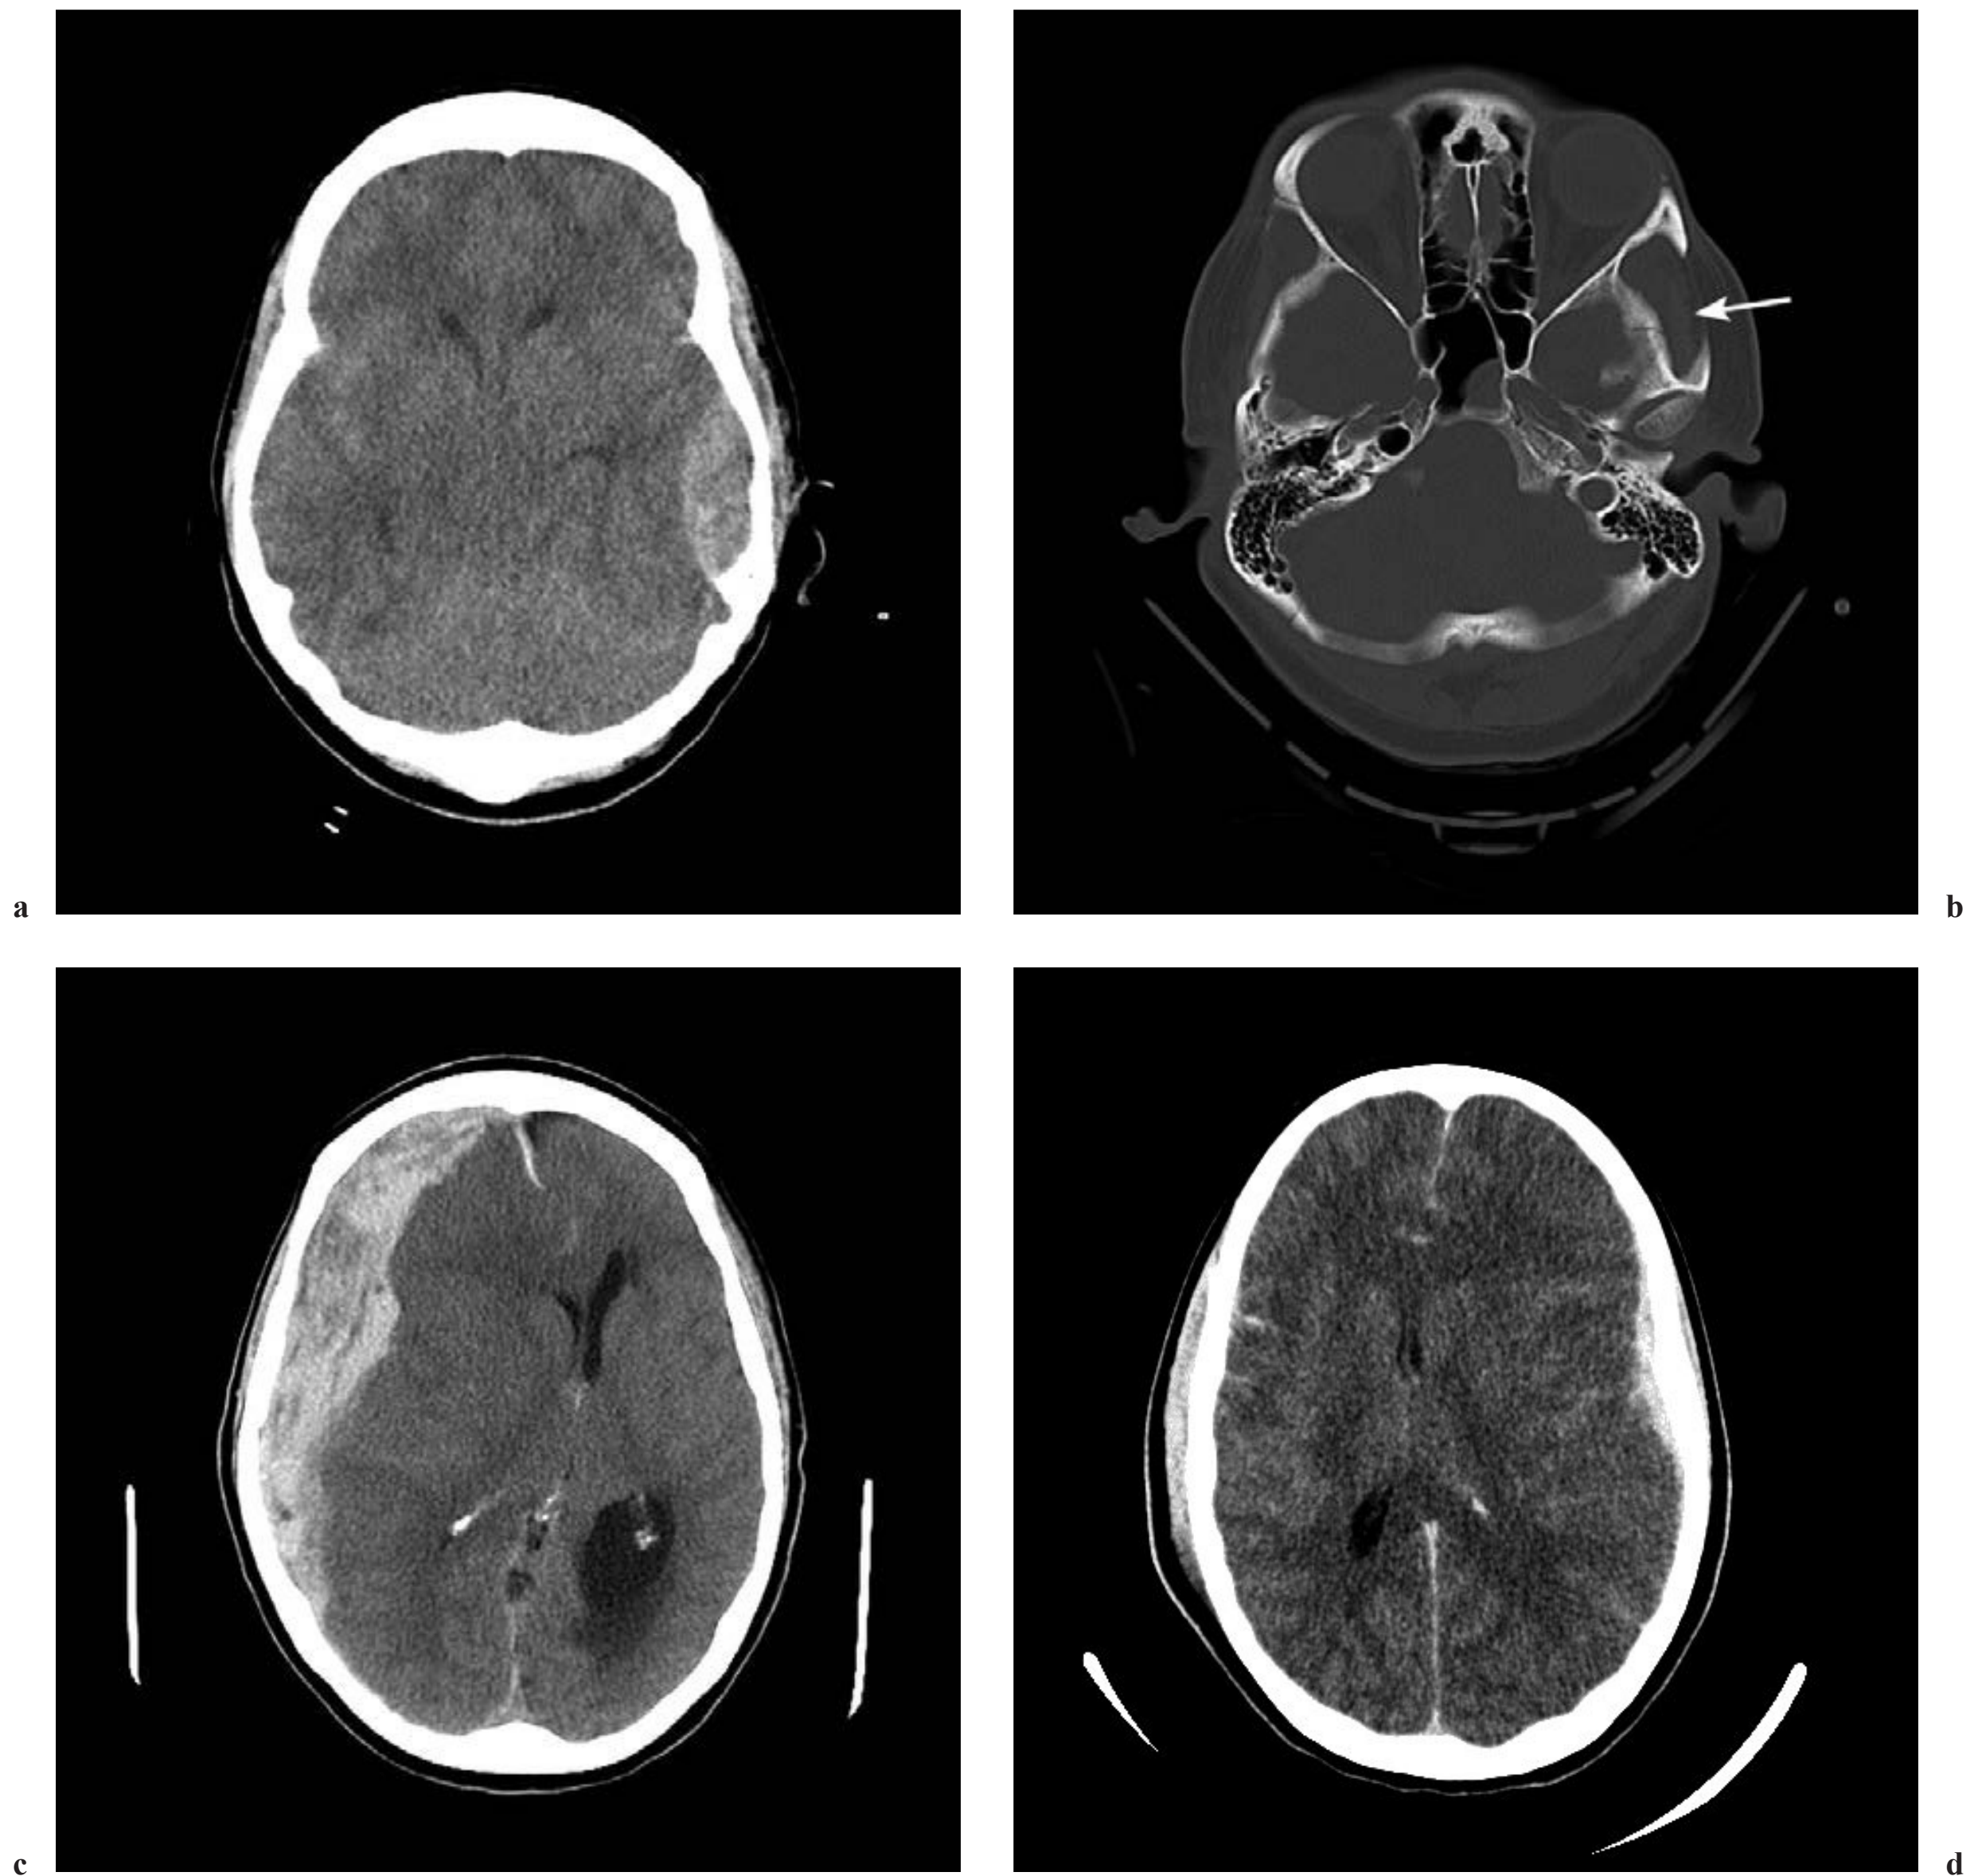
CT scan is the modality most commonly utilized in the perioperative setting. (a) Epidural hematomas demonstrate a characteristic convex shape (due to adherence of the dura at the suture lines) and are typically accompanied by a (b) fracture (arrow). (c) Subdural hematomas by contrast, are not bound by sutures and assume a crescentic appearance, layering over the convexity. (d) A small subdural hematoma may be accompanied by disproportionate mass effect and midline shift.
